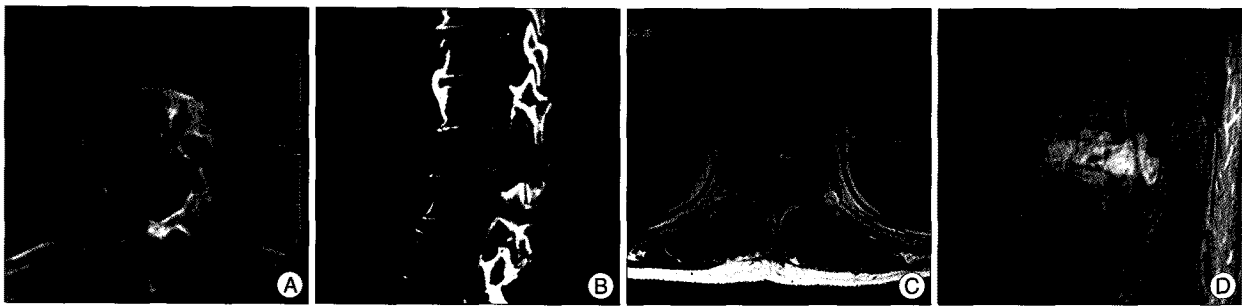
A : Axial and B : Sagittal reconstruction computed tomography (CT) scan demonstrate osteolytic lesion. The T11 vertebral body is collapsed and shows a pathologic fracture with trabecular and cortical destruction with involvement of both pedicles. C : The axial contrast-enhanced T1-weighted Magnetic resonance (MR) imaging showing multiple serpentine intralesional flow-voids. D : sagittal contrast-enhanced T1-weighted MR imaging demonstrating anterior and posterior bony involvement compresses the spinal cord at T11.
